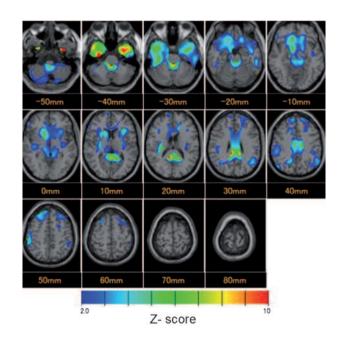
FDG PET z-score maps, displayed by overlaying on the anatomically standardized MRI image of healthy volunteers, showed remarkable reduction of the cerebral glucose metabolism in the bilateral temporal poles and mild reduction in the right striatum and posterior cingulated gyri.
